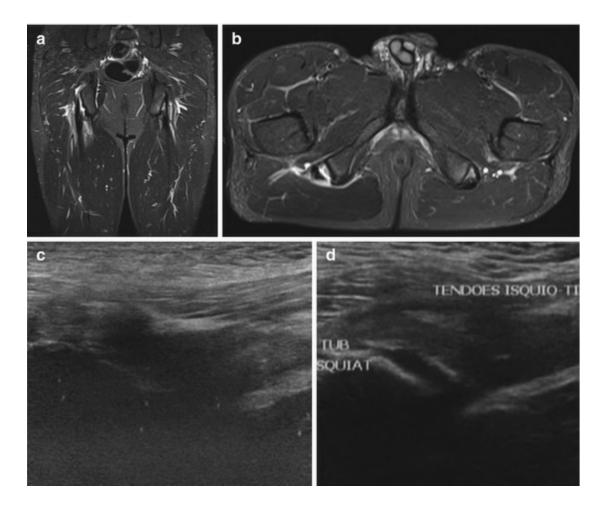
A 33-year-old male professional soccer player. Coronal (a) and axial (b) STIR MRI show partial rupture of the right hamstring tendons from the ischial tuberosity at their origin. Note also proximal tendinopathy of the left hamstring tendons associated with mild bone marrow edema. (c) Posterior longitudinal ultrasound image used to guide the injection of platelet-rich plasma shows retraction of the hamstring muscle insertions. (d) Ultrasound examination performed 30 days after platelet-rich plasma injection reveals reduction of the tendinous gap and partial recovery of the fibrillar pattern
